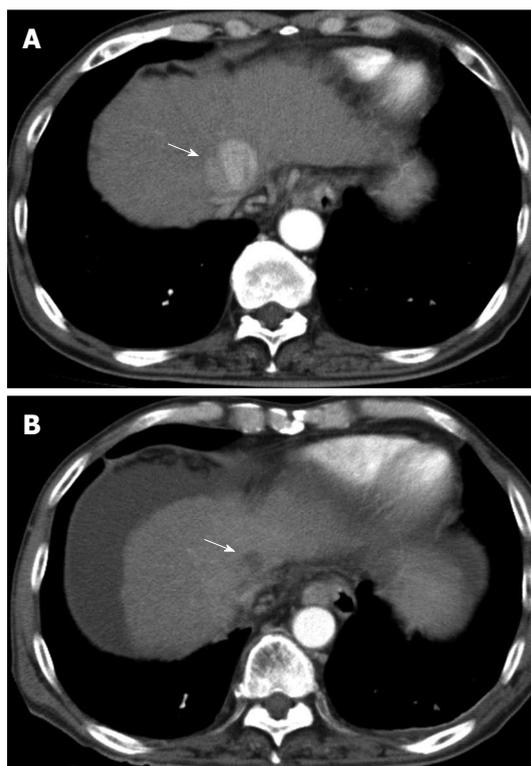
Clinical example of patient had late adverse events by CyberKnife®. A 66-year old male with hepatitis B virus cirrhosis received CyberKnife® therapy at a dose of 42 Gy in 3 fractions for hepatocellular carcinoma sized 40 mm in diameter in S4. The Child-Pugh score before the treatment was 7 and the score rose with 13 when 12 mo after the treatment. After he died of liver failure. A: Dynamic computed tomography (CT) scan in arterial phase before the treatment showed a hypervascular lesion in S4 (arrow); B: The lesion was showed as a hypovascular lesion on dynamic CT scan in arterial phase 12 mo after the treatment (arrow), but dynamic CT scan showed liver atrophy and massive ascites.
